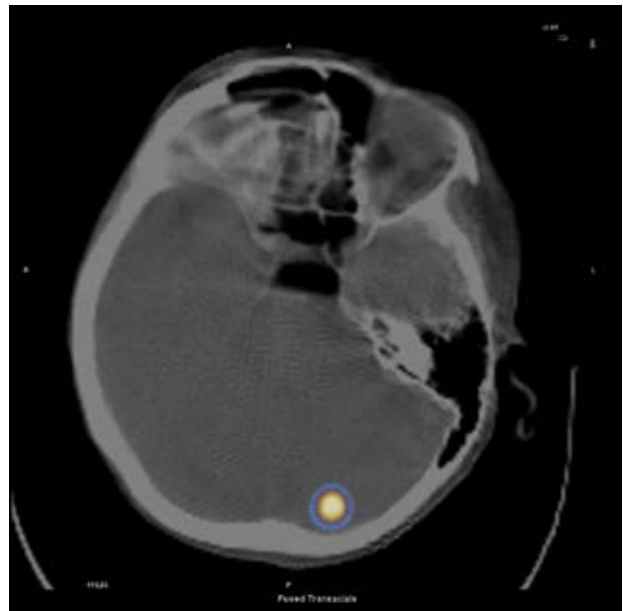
Focus of increased accumulation of Tc-99m-EDDA/HYNIC-TOC in the left cerebellar hemisphere visualised in SPECT/CT representing a cerebellar metastasis of papillary thyroid carcinoma
